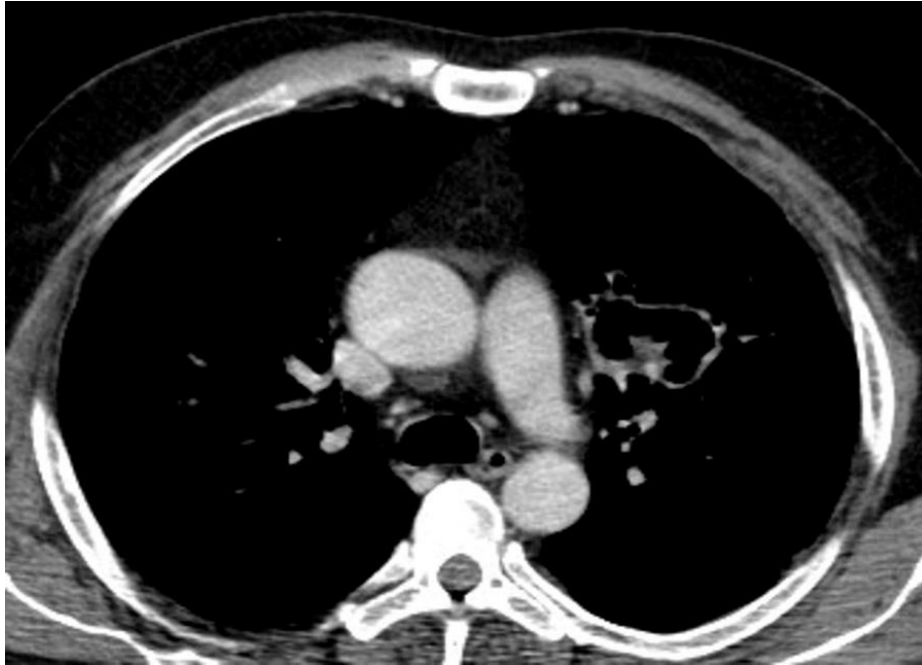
MRI chest of the patient reveals cavitation and fibrosis along the right upper lobe; confirming the presence of a cavitary lesion in the lung.
